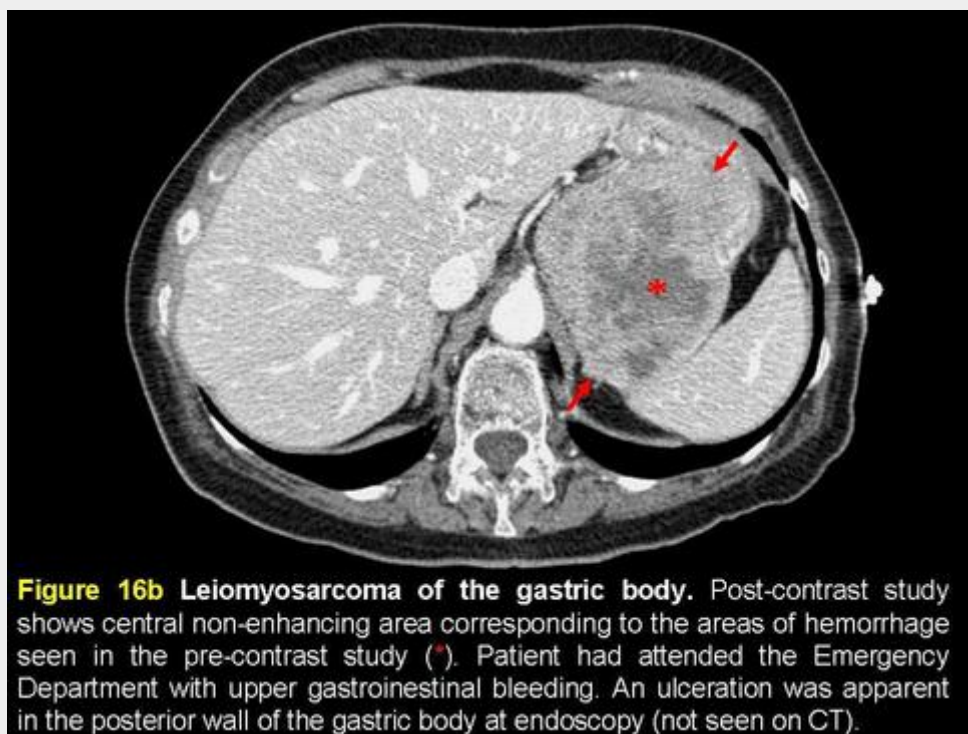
Leiomyosarcoma of the gastric body. Post-contrast study shows central non-enhancing area corresponding to the areas of hemorrhage seen in the pre-contrast study (*). Patient had attended the Emergency Department with upper gastrointestinal bleeding. An ulceration was apparent in the posterior wall of the gastric body at endoscopy (not seen on CT).
